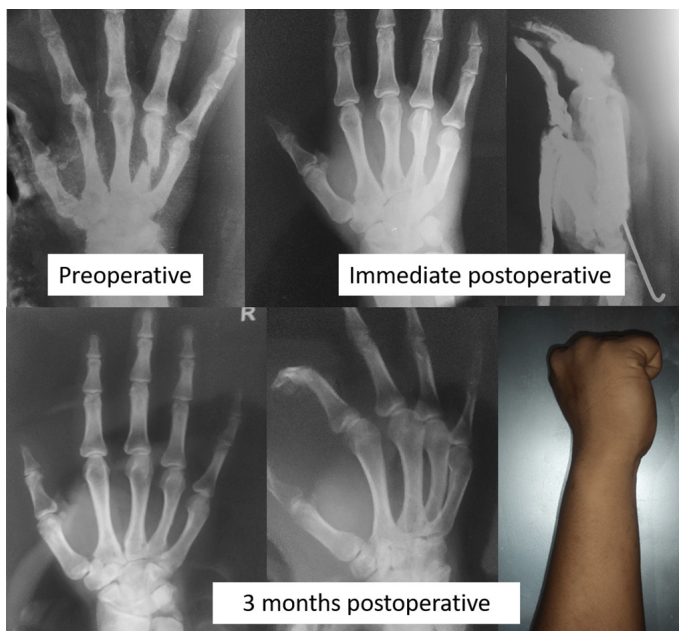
Preoperative, postoperative X-rays and clinical assessment showing good outcome in CRPP with K-wire in closed isolated 4th metacarpal fracture
